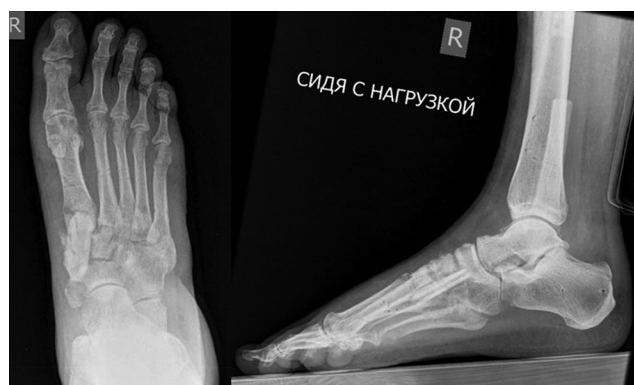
X-ray pictures of the patient's foot after Ilizarov frame removal (56 days after surgery)
